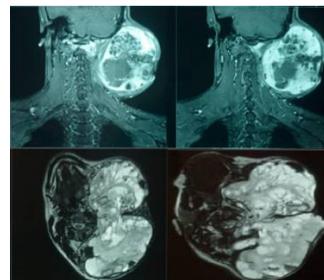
Magnetic resonance imaging (MRI) confirmed a large heterogeneous mass in the left parotid and lower temporal area, with extra-axial involvement
